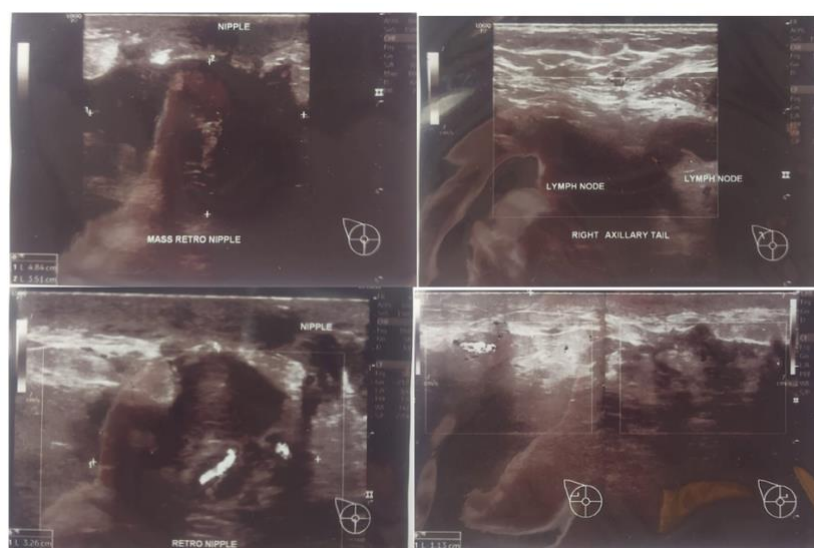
Patient's Breast Ultrasound
